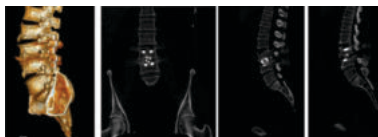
Postoperative CT Showing Grade 1 Fusion Based on Bridwell Grading System
